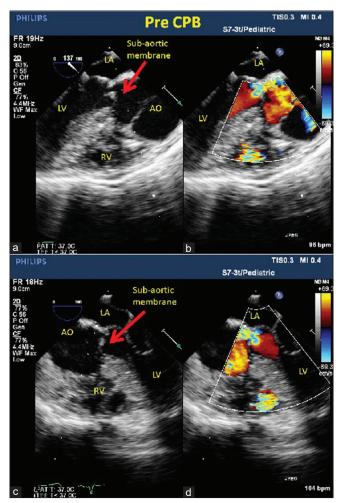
Subaortic membrane evaluation by TEE. (a) Midesophageal (ME) aortic valve long-axis view showing subaortic membrane with prominent subaortic septal hypertrophy, (b) Color doppler assessment of left ventricular outflow tract in ME aortic valve long-axis view showing turbulent flow at the level of subaortic membrane; (c) 2–D image of subaortic membrane in ME 5-chamber view; (d) Color doppler showing turbulence in left ventricular outflow tract originating near subaortic membrane (LA: left atrium; LV: left ventricle; RV: right ventricle; AO: aorta)
